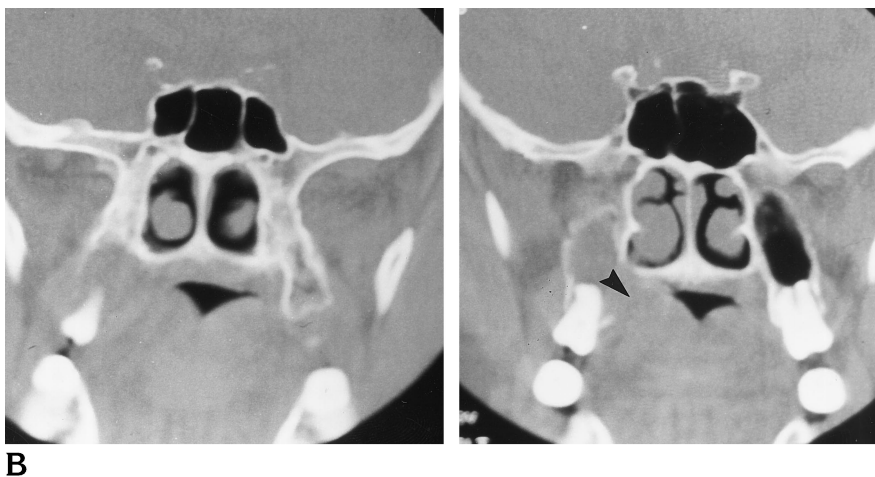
Sixty-six-year-old man with painless lump in the retromolar region of the right maxilla 5 years after cardiac transplantation. Coronal CT scans show a soft-tissue density in the right maxillary sinus with destruction of the maxillary tuberosity (*arrowhead*).
